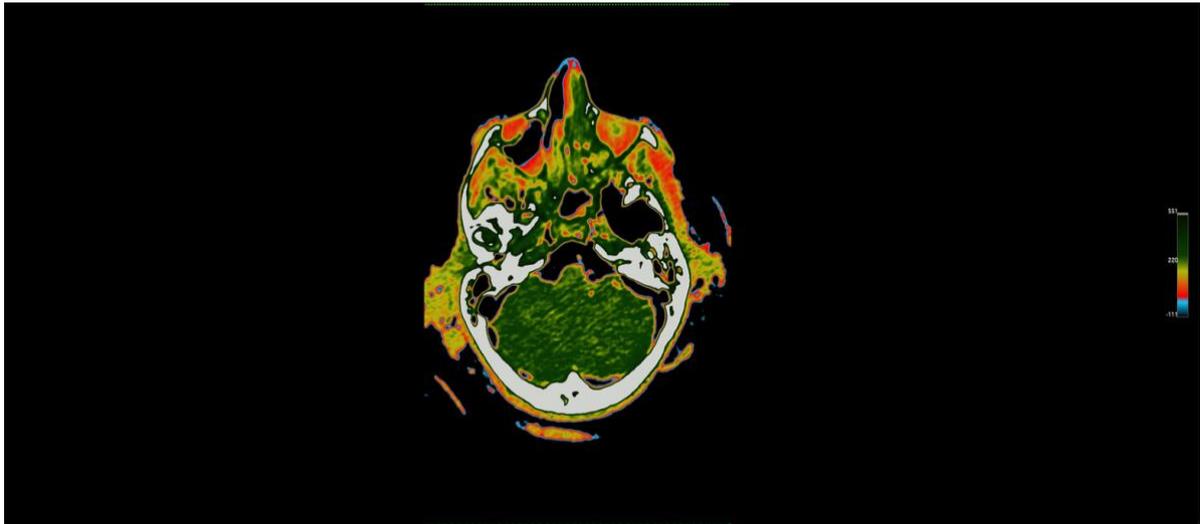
Axial plane CT slice 4.
